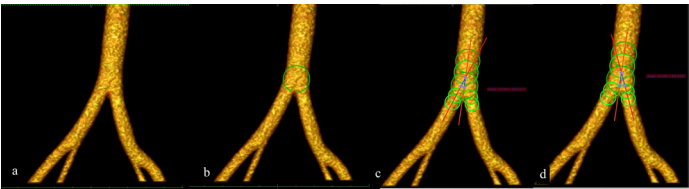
Conversion of two-dimensional computed tomography angiography images into 3D images. a: 2D CTA image in the transverse plane, b: 2D CTA image in the coronal plane, c: 3D reconstruction of the 2D CTA image, d: Ready-to-measure image of neighboring structures other than veins on the 3D image
